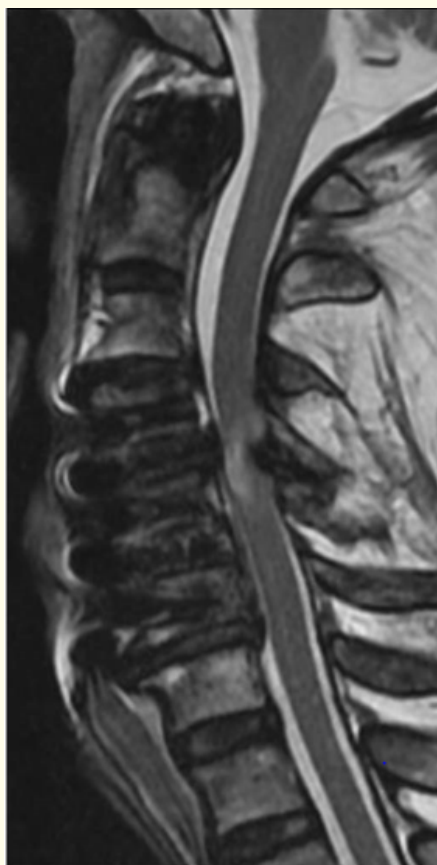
Postoperative sagittal T2-weighted MRI revealed secondary spinal cord compression due to buckling of the ligament flavum into the spinal canal at the C4/5 level.
